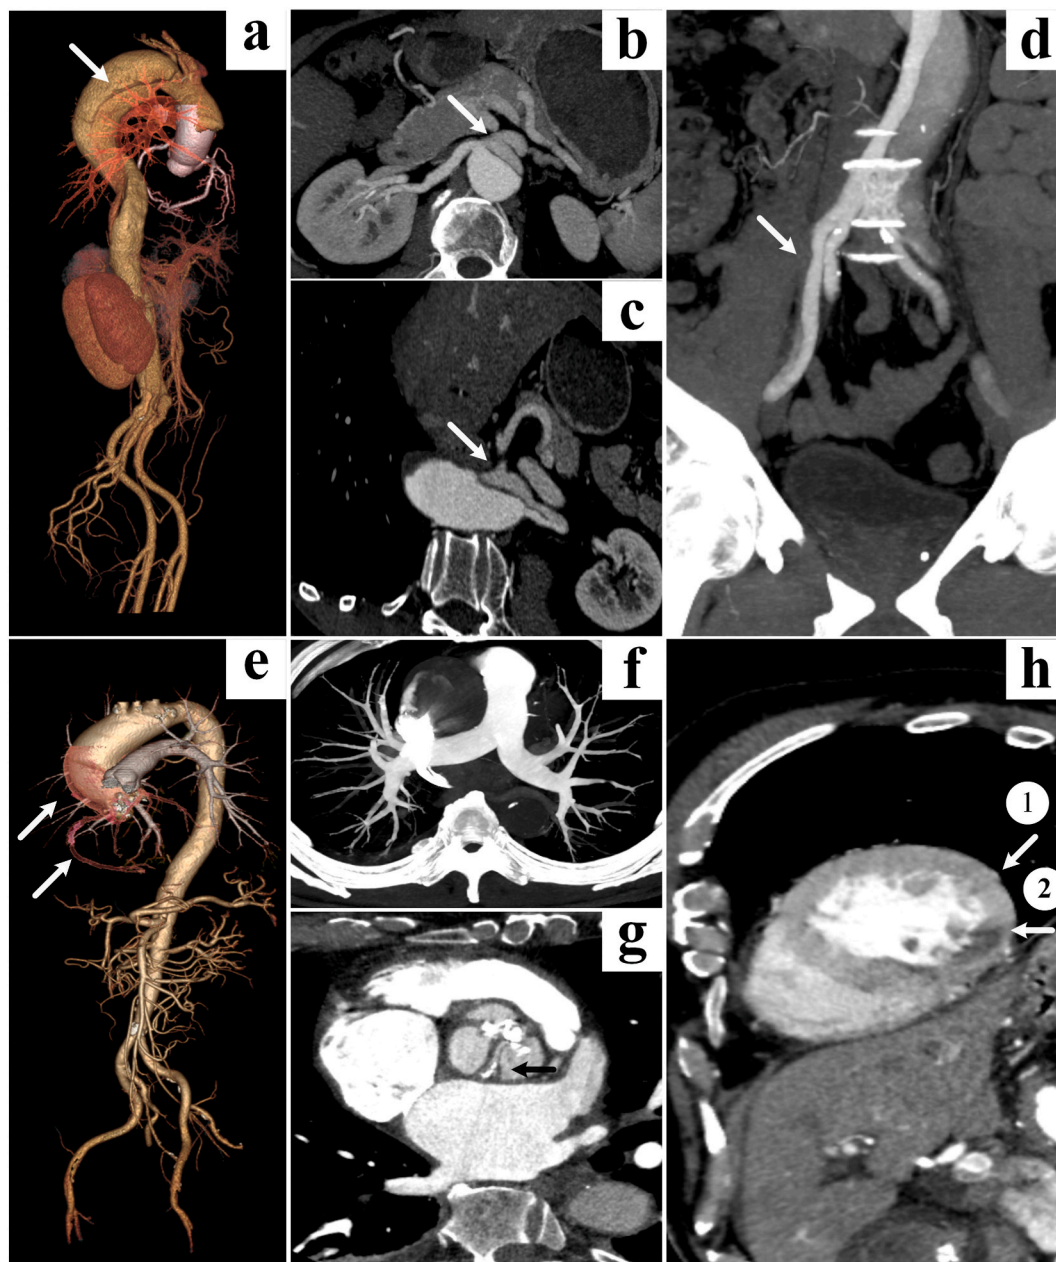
Case Studies Using Triple-Rule-Out CT Angiography (TRO CTA)
